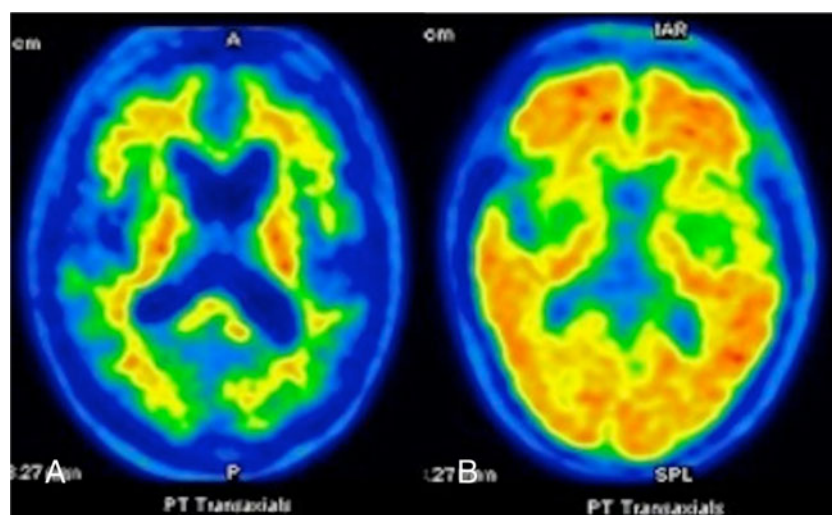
Axial images of an amyloid PET CT using the tracer ^{11}C -PIB in a patient with progressive supranuclear palsy (PSP) (a) and Alzheimer's disease (b). The patient in a shows normal distribution of the tracer, whereas the patient with AD shows a high tracer uptake in the cortices of the frontal, temporal and occipital lobes consistent with a heavy amyloid burden
